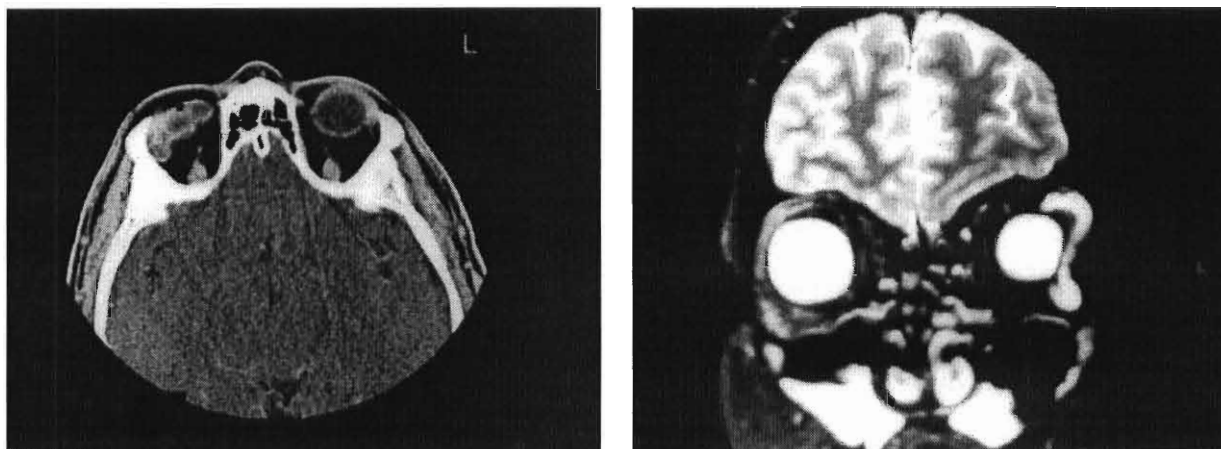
(Left panel) Computed tomography scan showing a hydrogel explant in the anterior orbit of the right eye. (Right panel) Magnetic resonance image of the left orbit shows an expanded hydrogel explant.
